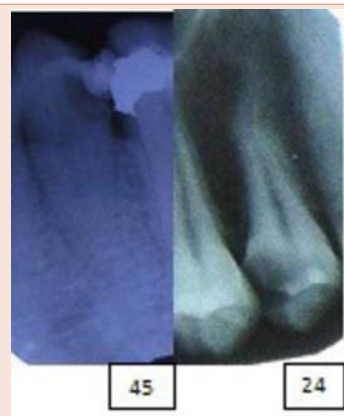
Preoperative IOPA radiograph of teeth #45 and #24.
